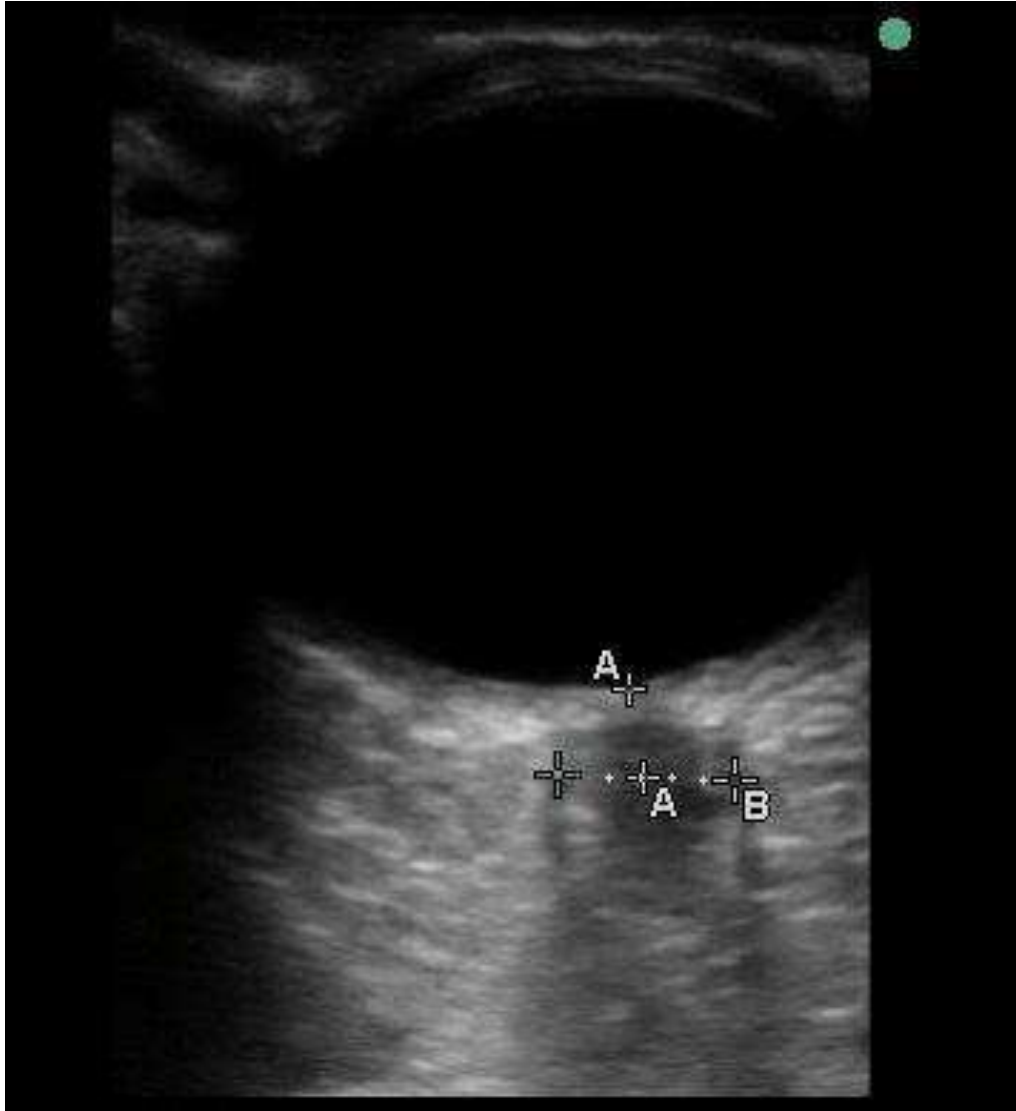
Measurement of Optic Nerve Sheath Diameter using ultrasound
